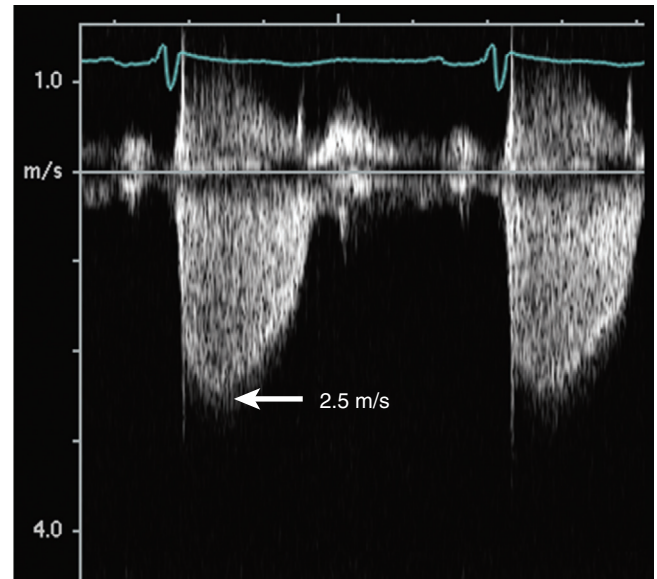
■ Peak pressure gradient is calculated using peak velocity (V) from the continuous Doppler tracings of the tricuspid regurgitant jet using the simplified Bernoulli equation. Peak velocity of 2.5 m/s corresponds to a peak pressure gradient (right ventricular systolic pressure) of 25 mm Hg. Pulmonary arterial systolic pressure is obtained by adding estimated right atrial pressure to the peak gradient.
